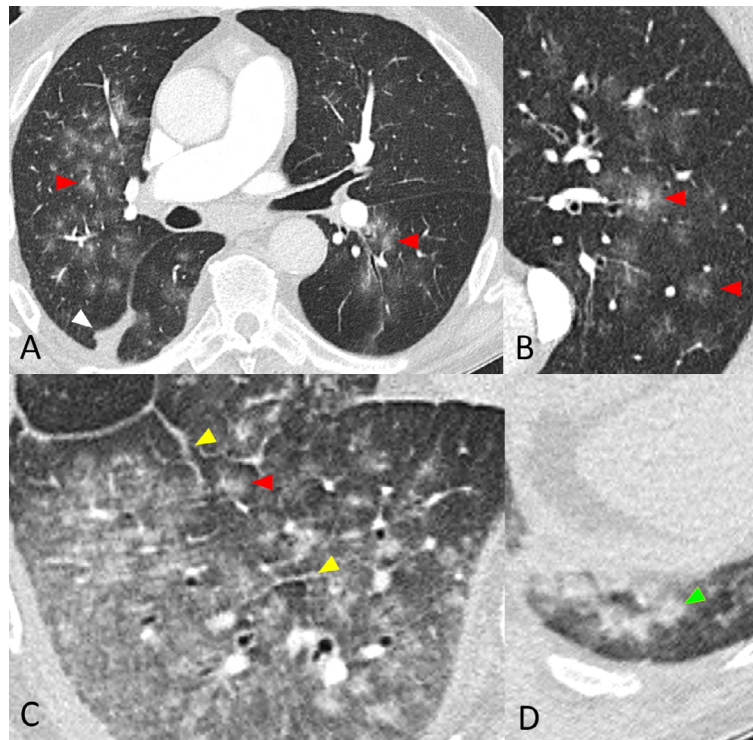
Contrast-enhanced chest CT in axial lung window reconstructions with 1.25 mm slice thickness. (a) Bilateral asymmetric centrilobular consolidations and GGO in a random distribution (red arrowheads) with a small pleural effusion (white arrowhead). (b) Centrilobular consolidation with a perilesional halo (red arrowheads). (c) Interlobular septal thickening (yellow arrowhead) with centrilobular consolidations (red arrowhead) in the right lower lobe. (d) Patchy confluent consolidations in the dorsobasal left lower lobe (green arrowhead). CT = computed tomography, GGO = ground glass opacities.
